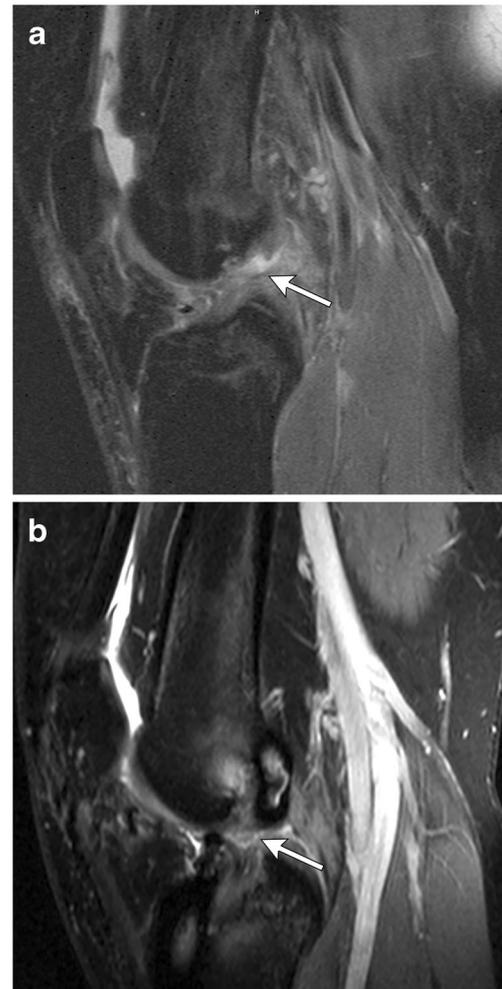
ACL tear and subsequent re-tear of ACL graft in a 16-year-old girl soccer player. a Sagittal proton density fat-saturated MR image through the knee demonstrates complete disruption of ACL fibers (*arrow*) with abnormal orientation. b Sagittal proton density fat-saturated MRI image of the same patient following ACL graft repair demonstrates complete tear of the ACL graft (*arrow*)
